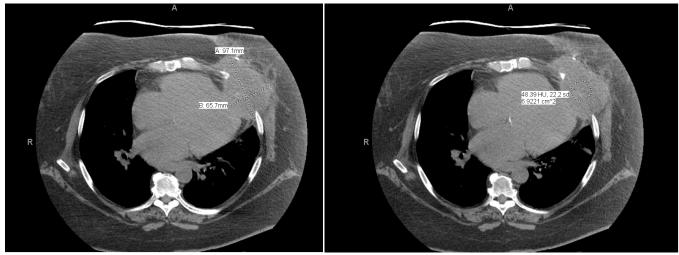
LVI-CT of the chest without contrast. *LVI-CT*, left ventricular index-computed tomography
